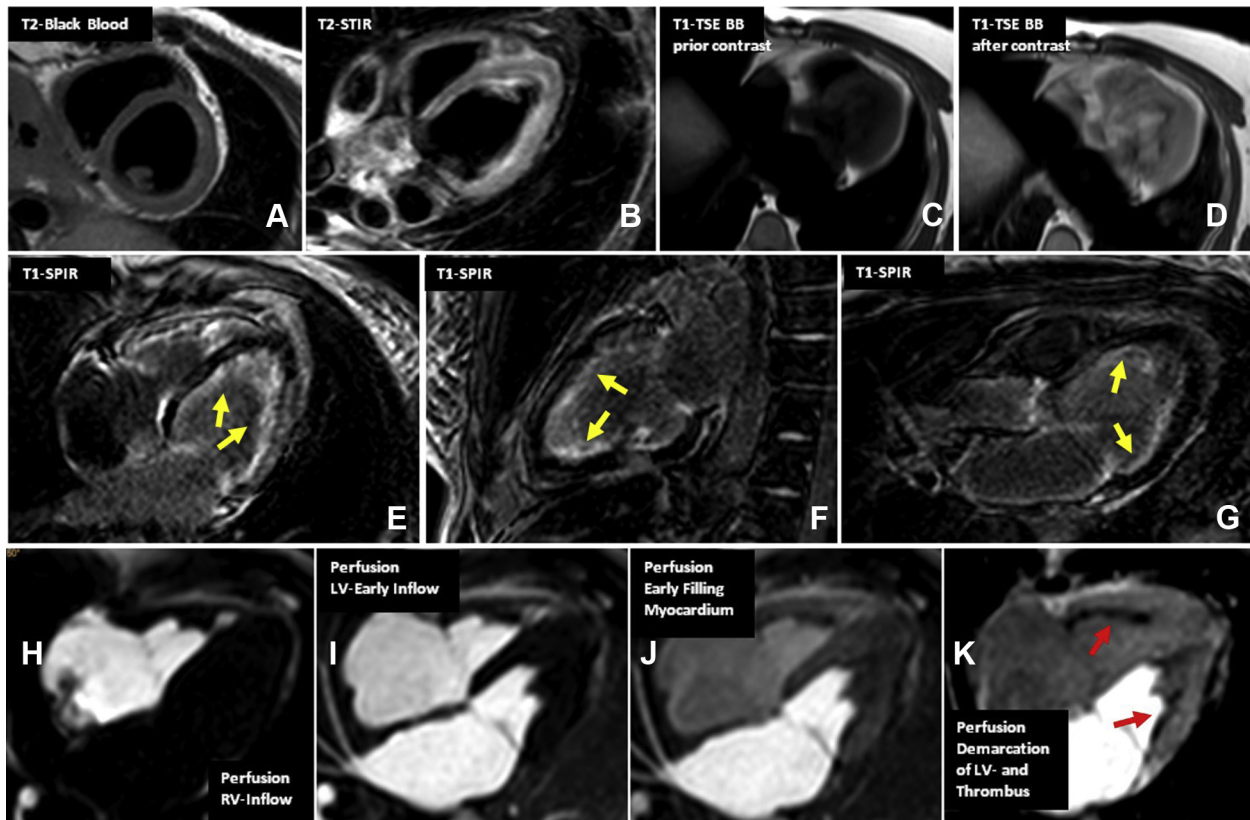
Cardiac magnetic resonance imaging myocardial tissue characterization by T2 black blood sequences characterizing pericardium (A), T2-STIR sequences showing myocardial edema (B), T1 black blood sequences prior (C) and directly after contrast administration (D) showing hyperemia, and T1-SPIR sequences of the four-chamber view (E), two-chamber view (F), and three-chamber view (G) suggestive of fibrosis through LGE (yellow arrows). Cardiac magnetic resonance perfusion imaging (H-K) documents contrast-enhanced signals in the myocardium and demarcation of subendocardial thrombus formation in the RV and LV. Thrombotic lesions show no contrast enhancement (red arrows).
